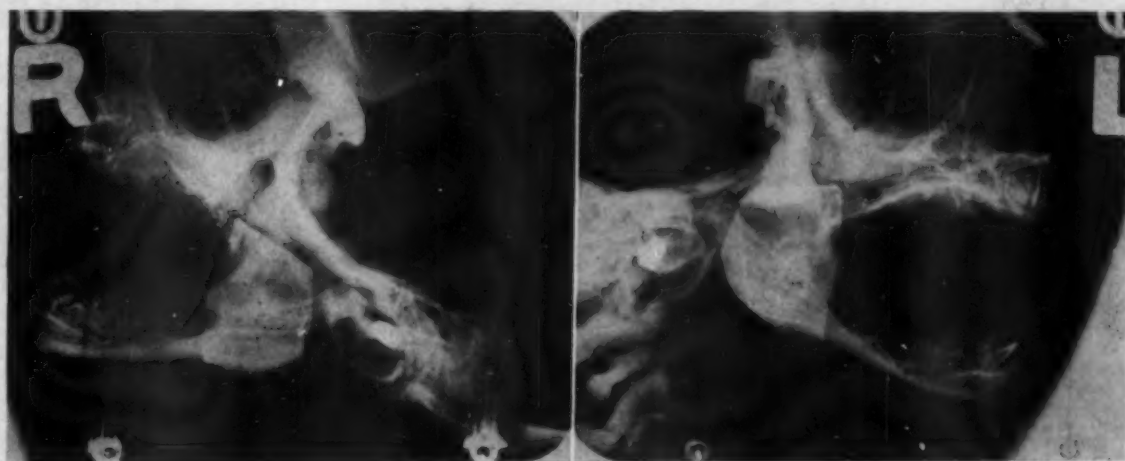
The roentgenogram of the left mandible shows the slightly radiopaque meniscus clinging to the head of the condyle, while the roentgenogram of the right condyle shows a definite radiolucent line similar in character to the epiphyseal line seen in the long bones.
